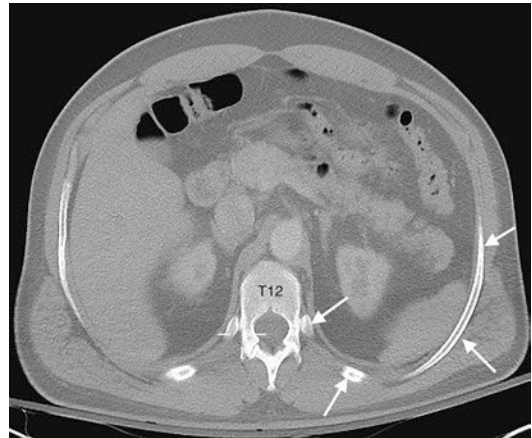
Anatomy of a floating rib. Axial CT image reconstructed in the oblique axial plane at the T12 level shows segmental visualization of the 12th rib (*arrows*)
